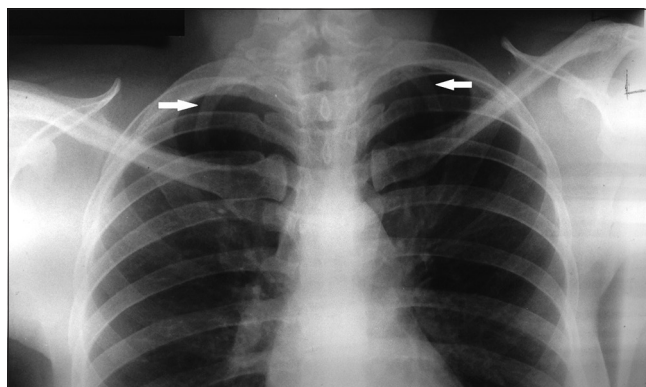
PA chest radiograph showing bilateral cervical ribs (white arrows)
